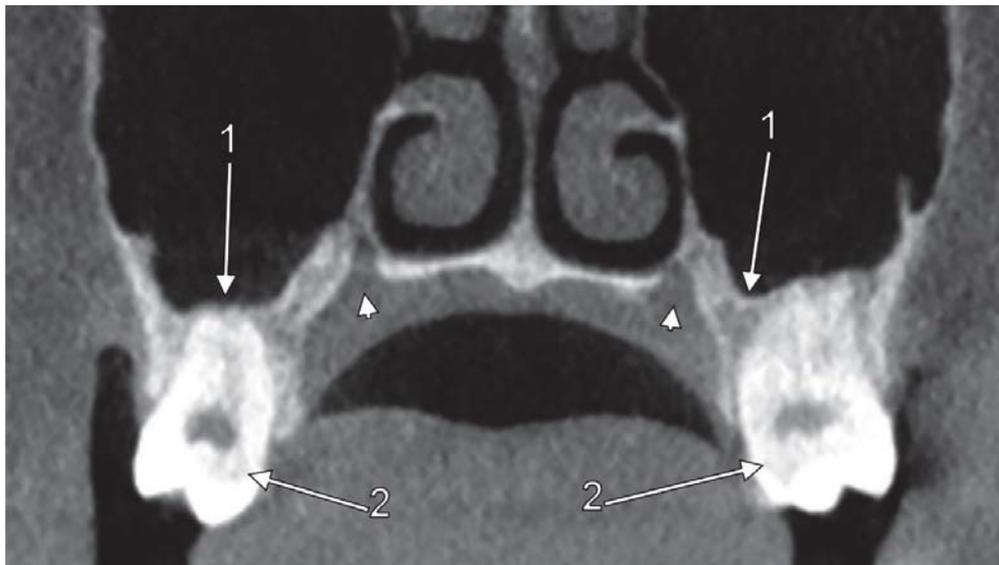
Coronal CBCT slice through the greater palatine foramina (arrowheads). 1.maxillary sinus floor; 2.third maxillary molars
